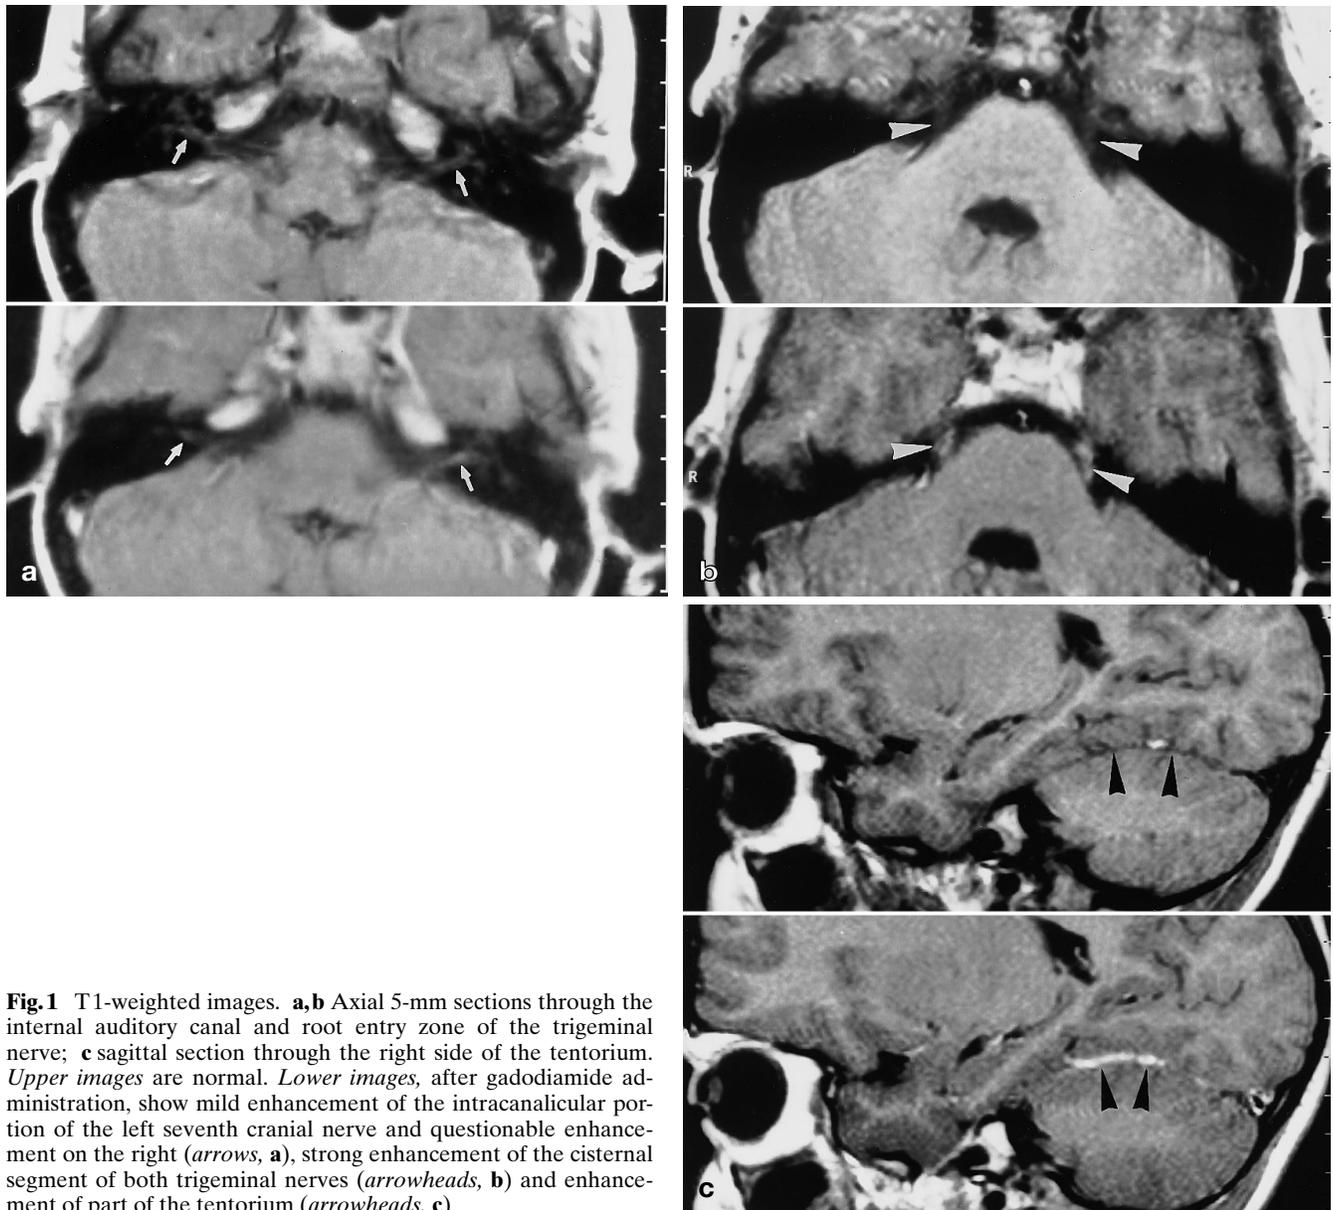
T1-weighted images. a,b Axial 5-mm sections through the internal auditory canal and root entry zone of the trigeminal nerve; c sagittal section through the right side of the tentorium. *Upper images are normal. Lower images, after gadodiamide administration, show mild enhancement of the intracanalicular portion of the left seventh cranial nerve and questionable enhancement on the right (arrows, a), strong enhancement of the cisternal segment of both trigeminal nerves (arrowheads, b) and enhancement of part of the tentorium (arrowheads, c)*
